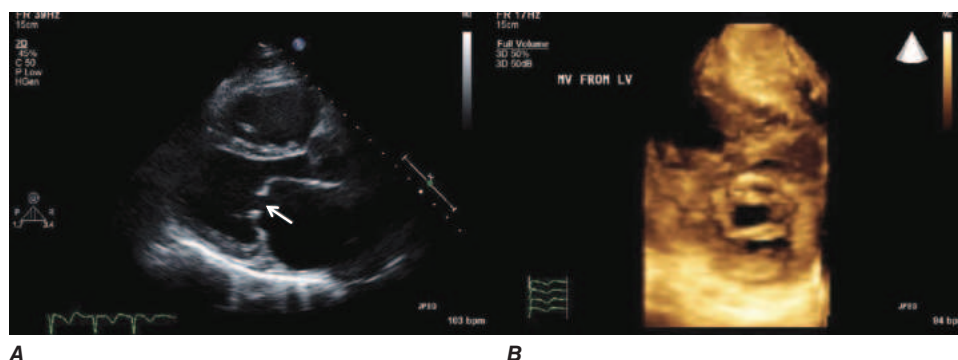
A. Rheumatic mitral stenosis showing pliable leaflets tethered at the tips (arrow). Note the characteristically enlarged left atrium. B. Mitral stenosis visualized from a three-dimensional echocardiogram.
